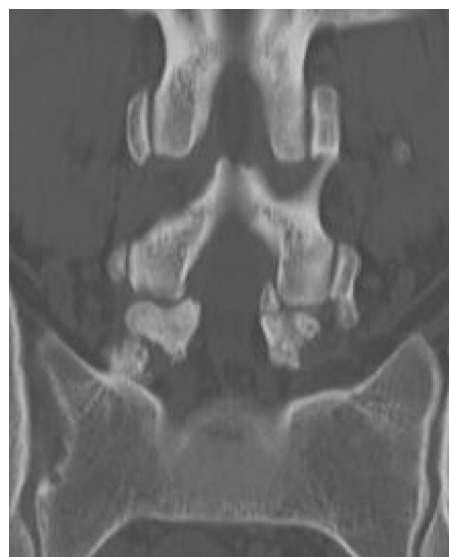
Pre-operative CT coronal cut image showing bilateral pars defects.
